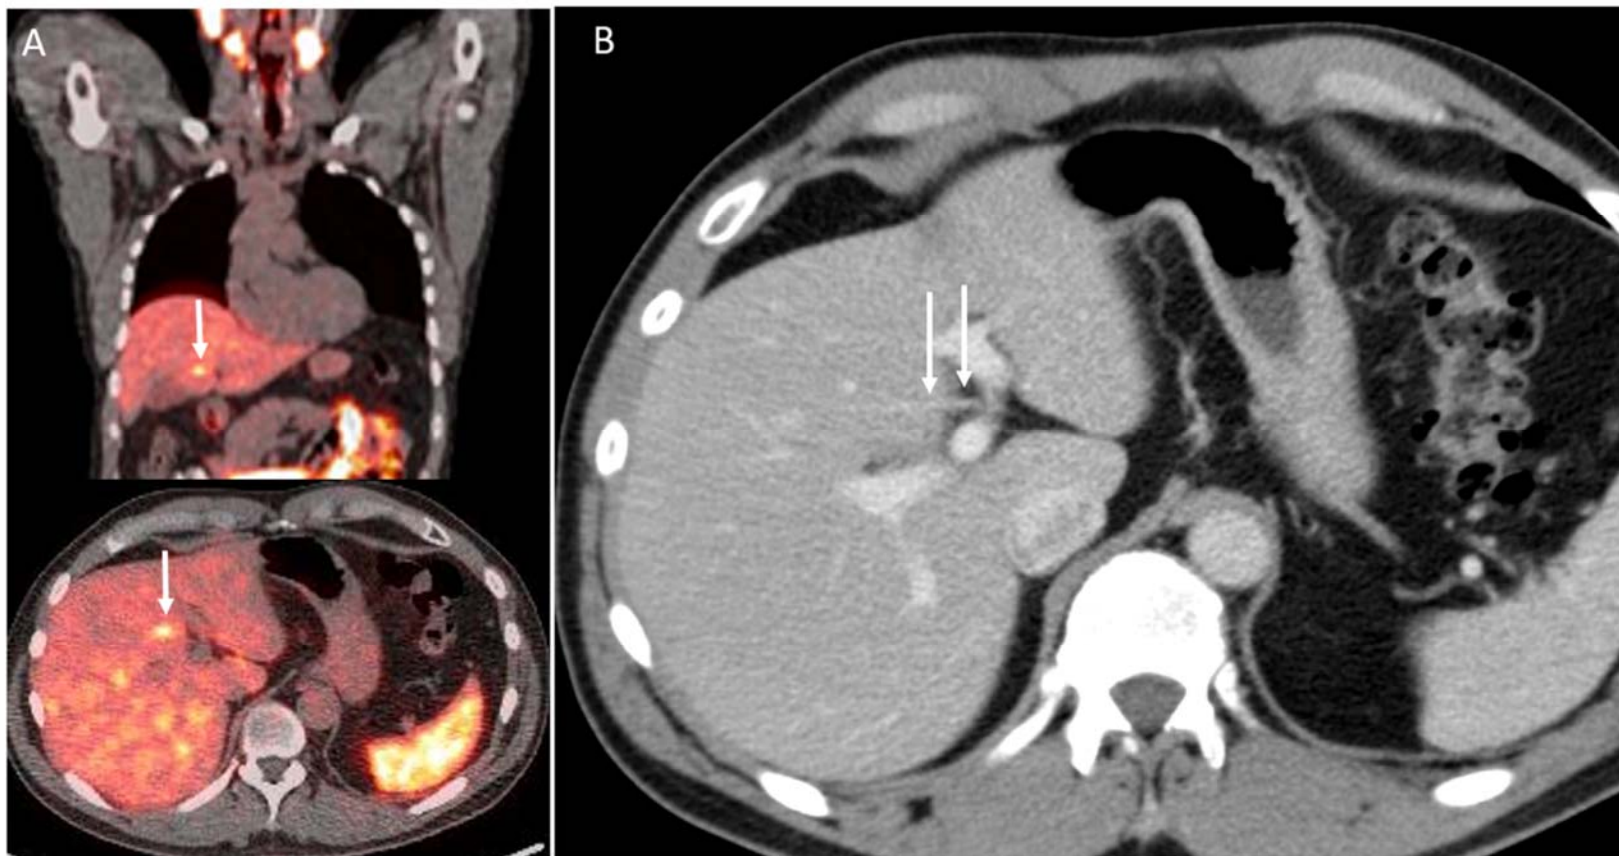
Case 2: A 58-year-old man status post radical prostatectomy for PCa (Gleason 4+3) had ^{68}Ga -PSMA PET/CT for evaluation of biochemical recurrence at a PSA of 0.34 ng/mL. PET/CT did not reveal any site of recurrence but showed mildly increased focal radiotracer avidity at hepatic segment IVb (fused coronal and trans-axial PET/CT image - A). Contrast-enhanced CT (ceCT) done two weeks prior (trans-axial image - B) showed no abnormality in the hepatic parenchyma, but an aberrant vessel entering hepatic segment IV (arrows), similar to case 1. This case supports a pattern of hepatic vascular variant associated with artifactual segment IVb avidity on PSMA PET.
